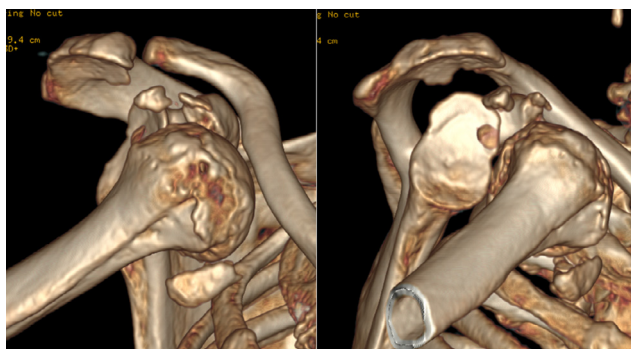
Initial 3D CT images of the coracoid process fracture and anterior dislocation.
